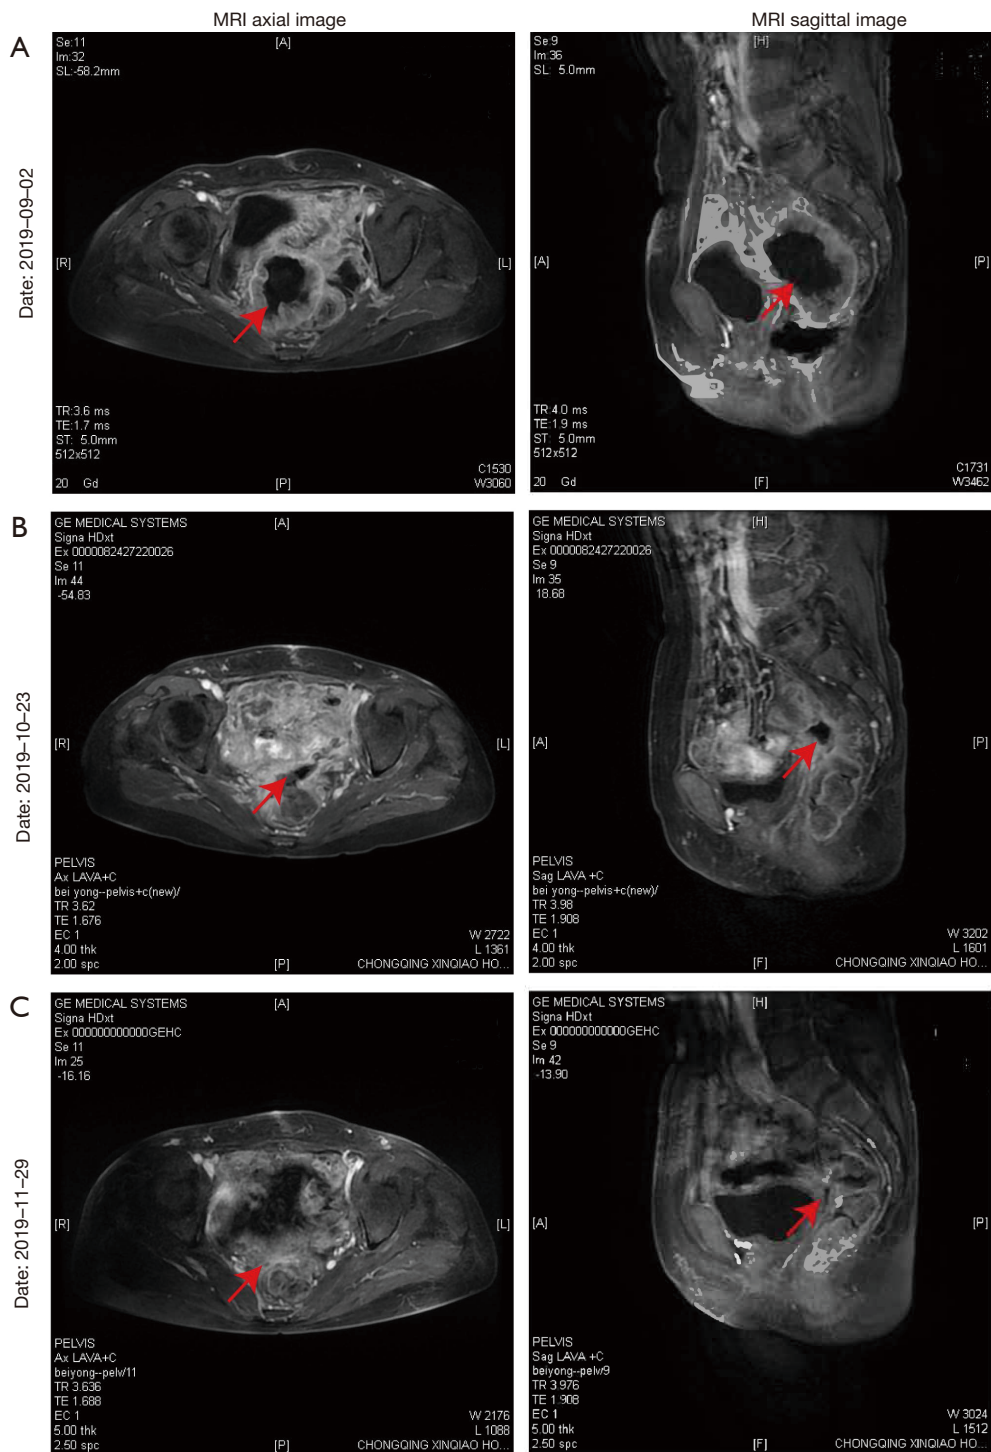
A series of magnetic resonance imaging (MRI) images showed the effect of immunotherapy combined with antiangiogenic drug therapy on the pelvic metastases. (A) On September 2 (nearly a month after the second operation), obvious multiple pelvic metastases (approximately 8.45 cm × 5.9 cm for the larger mass) indicated recurrence happened after the second operation; (B) on October 23, the pelvic metastasis was significantly reduced and shrunk (approximately 2.3 cm × 2.0 cm in size), showing the efficacy of the two cycles of immunotherapy combined with antiangiogenic drugs therapy; (C) on November 29, the pelvic metastasis was further reduced and shrunk (approximately 1.0 cm × 0.9 cm in size), showing further efficacy after the two more cycles of immunotherapy. The arrow indicates the location of the lesion.
